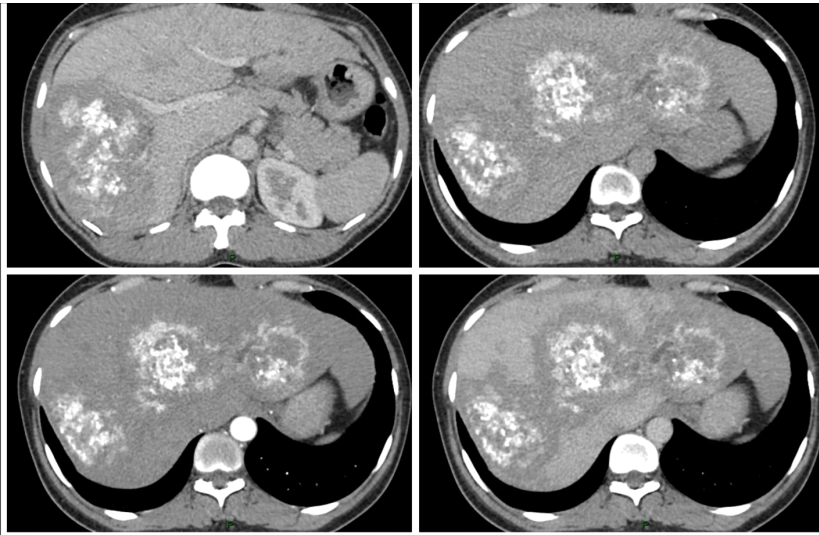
Contrast Enhanced CT Abdomen showing multiple liver lesions with internal hyper densities and calcifications with surrounding hypo densities in both lobes.
